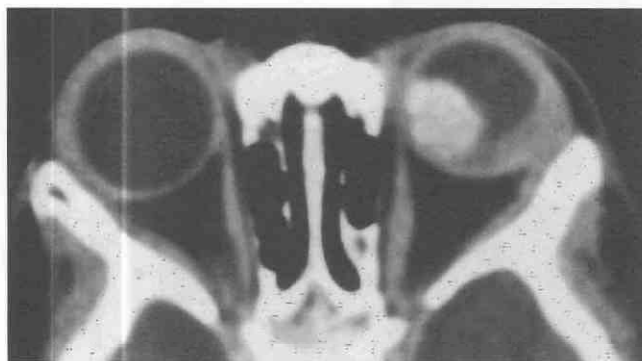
Axial contrast-enhanced CT scan shows calcified retinoblastoma of the left eye.
